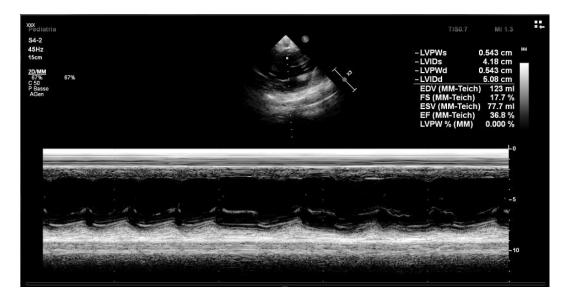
Echocardiographic image of a 25-year-old patient in our cohort, conducted at our Institute, that shows left ventricle dilated, globular, thinning walls, global hypokinesia, resulting in a severe reduction of global systolic function.
